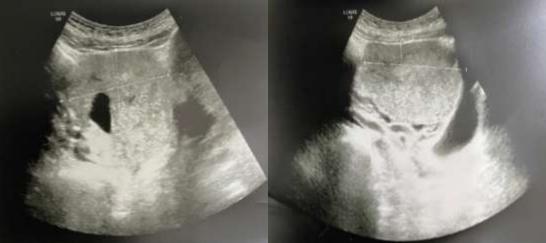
Ultrasoundfindings showing an ovarian cystic and solid tumor, with ascites.
